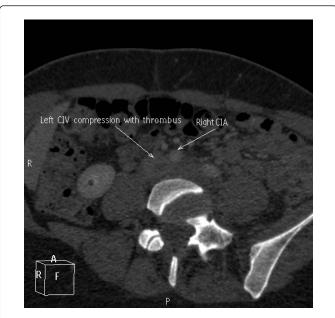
Initial axial CT image demonstrating left iliac artery relation to left iliac vein.
